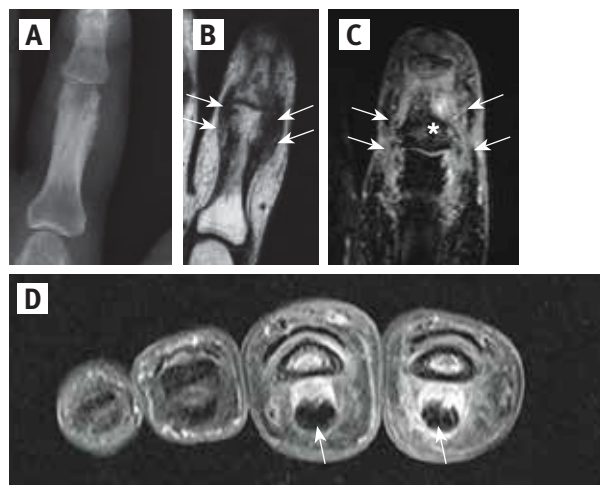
An anteroposterior radiograph [A], T1w [B], and T1w with fat saturation after gadolinium injection [C] images of the proximal interphalangeal joint of the hand of a patient with psoriatic arthritis (PsA) demonstrating enthesitis of the collateral ligaments with thickened and hyperintense ligaments as well as insertional osteitis (asterix). Coronal T1w with fat saturation after gadolinium injection [D] image of the hand of a different patient with PsA and dactylitis demonstrated tenosynovitis of the 2nd and third flexor tendons (arrows) as well as osteitis of the adjacent bones
